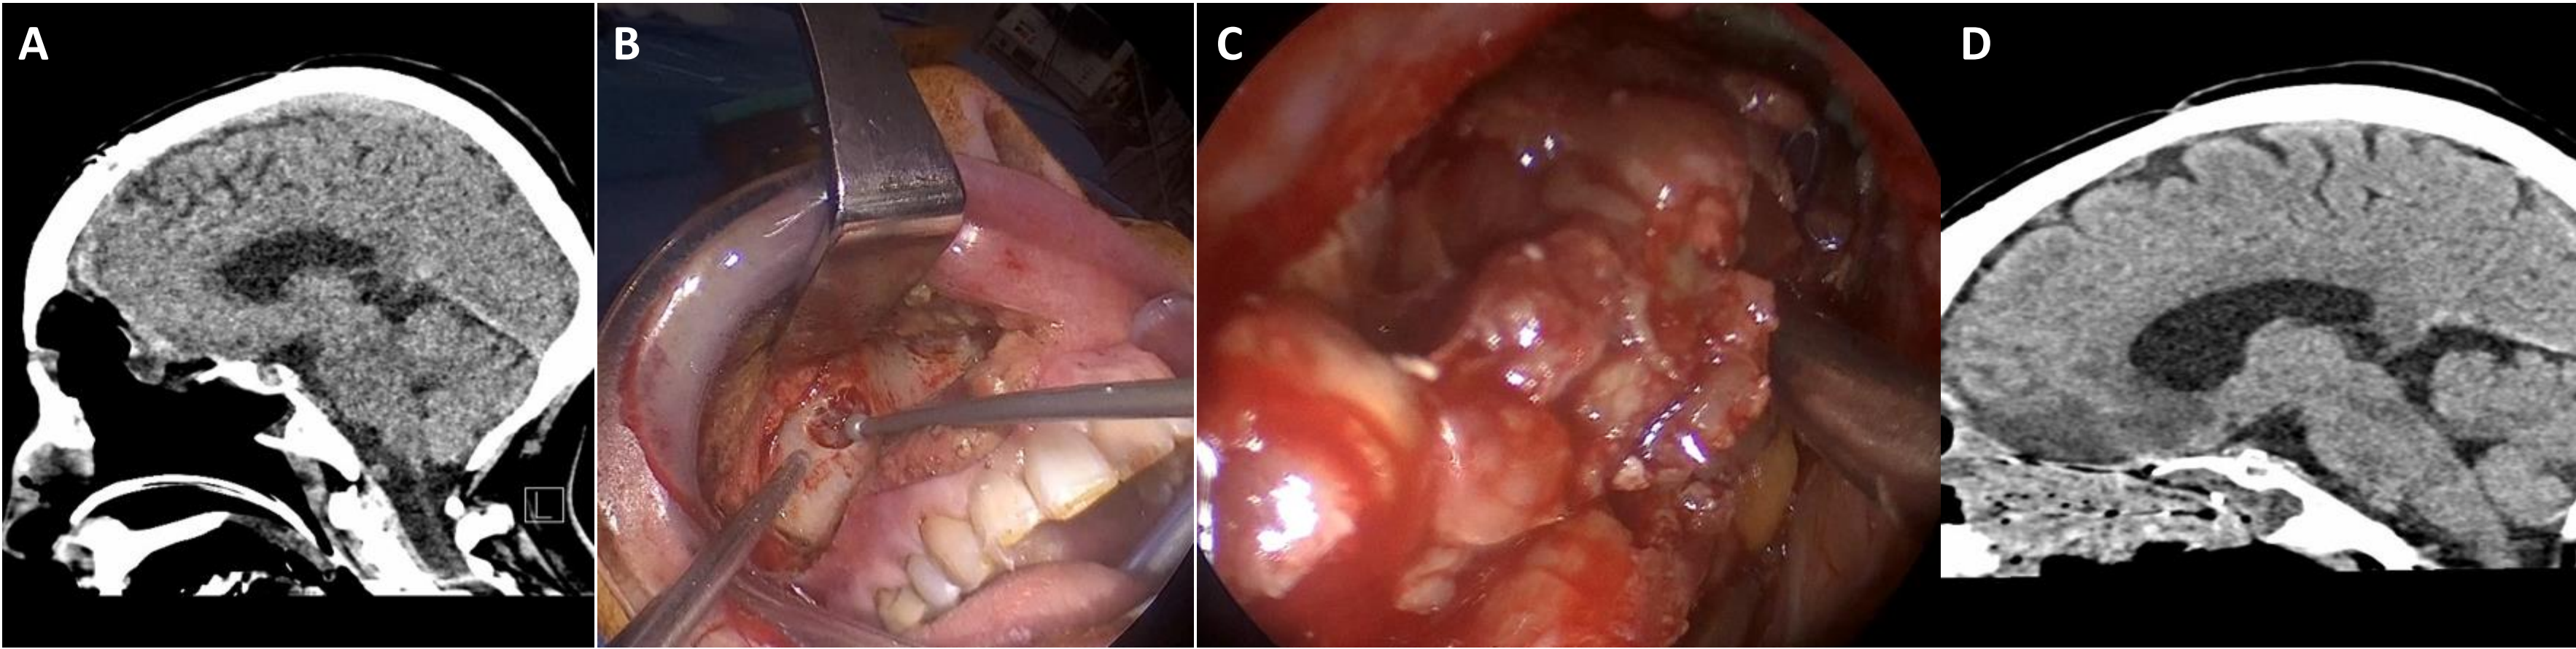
A) Sagittal view of pre-operative CT scan showing anterior fossa defect. B) Drilling anterior maxillectomy via sublabial approach to create tunnel for flap inset. C) Endoscopic inset of flap after placement through transmaxillary corridor. D) Sagittal view of post-operative CT scan showing flap in place along anterior fossa.
